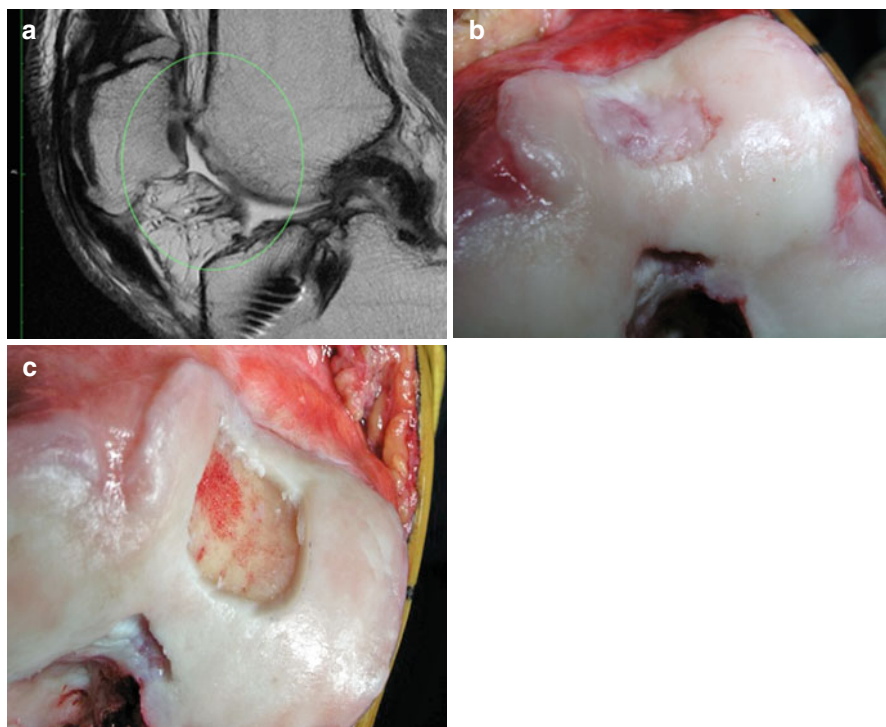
(a) Preoperative magnetic resonance imaging (*upper left*), (b) intraoperative picture of intralesional osteophyte (*upper right*), (c) intraoperative picture of subchondral bone after intralesional osteophyte removal (*bottom*)
